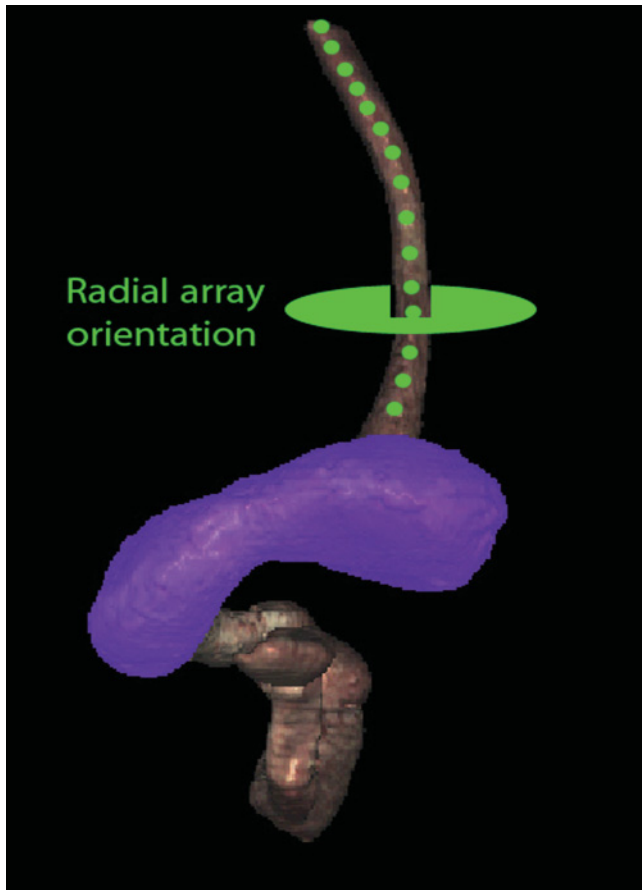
Visible Human Model of esophagus, stomach, and duodenum. The green circle shows a plane perpendicular to the axis and is similar to a plane developed during radial array endosonography.
